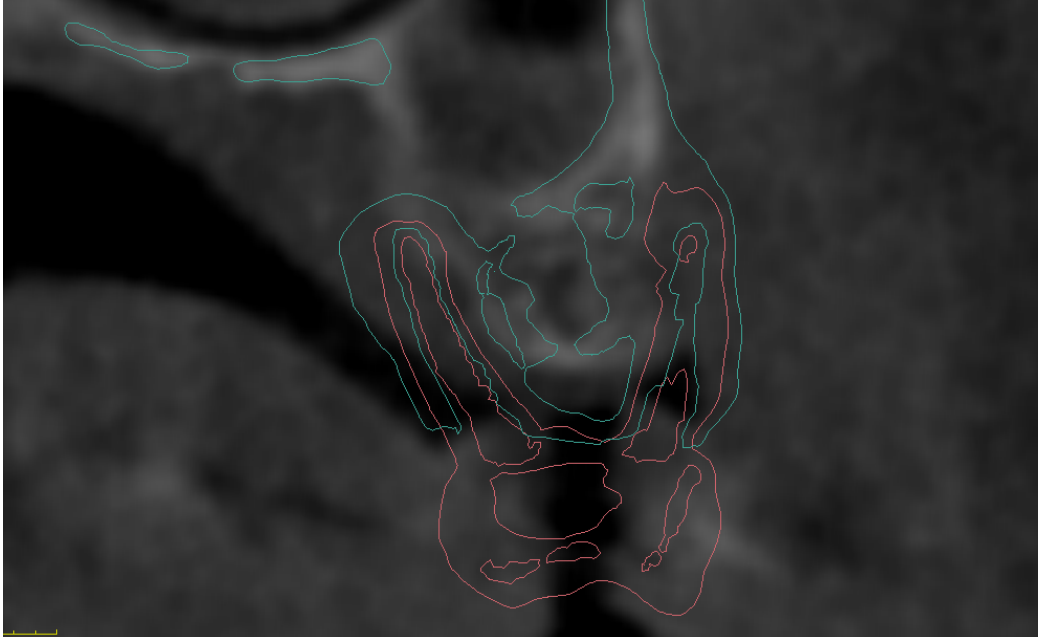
Cross-sectional view of CBCT.
